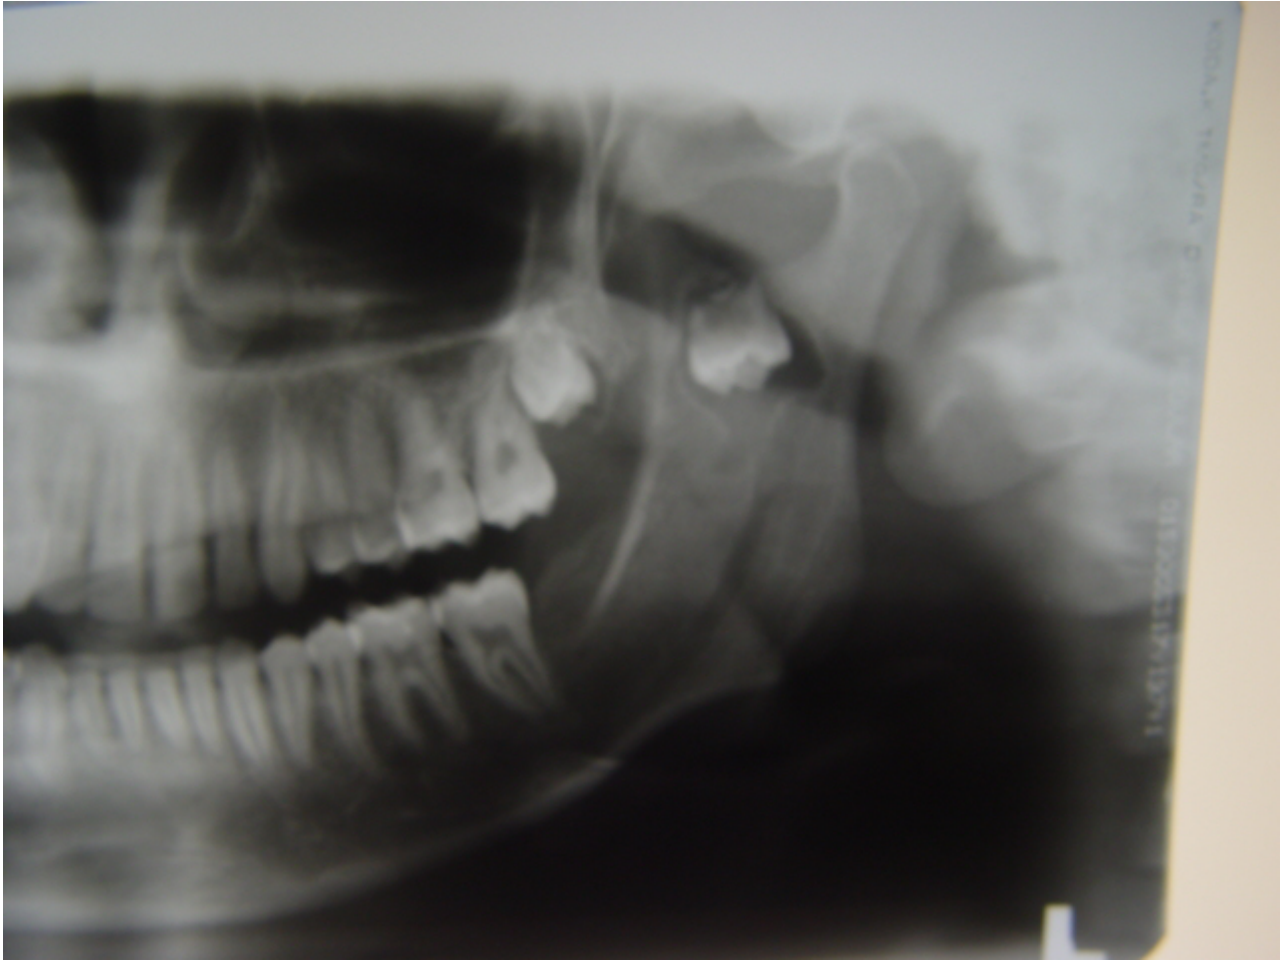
Radiographic Exam.
